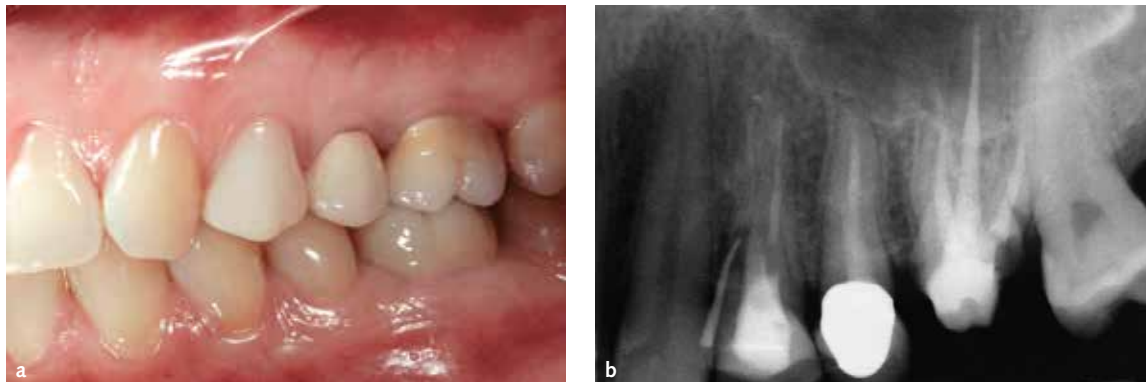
a) Left maxillary first premolar that was to be extracted due to a vertical root fracture. b) preoperative periapical radiograph with gutta-percha cone through the fistula and root fracture.
